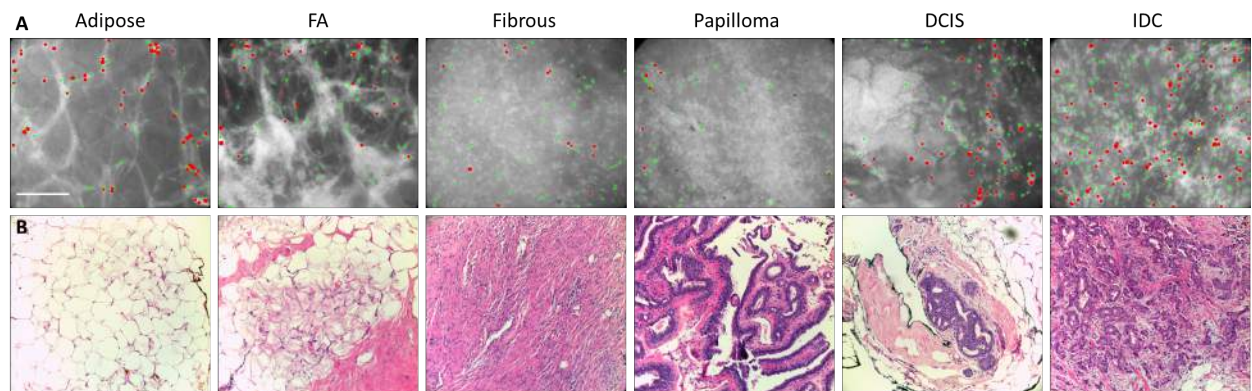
Application of sparse decomposition (SD) and circle transform (CT) to representative images taken from the site level data set. The original images were analyzed using SD, and nuclei were subsequently quantified with CT. An overlay is shown in A in which the smaller nuclei (<7 μm diameter) are false colored green and the larger nuclei (≥ 7 μm
